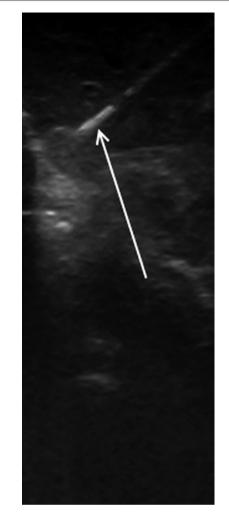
A practical application of intraoperative ultrasound is biopsy. Depicted here is the intraoperative biopsy of a hypoechoic lesion (*white arrow*: biopsy needle)
